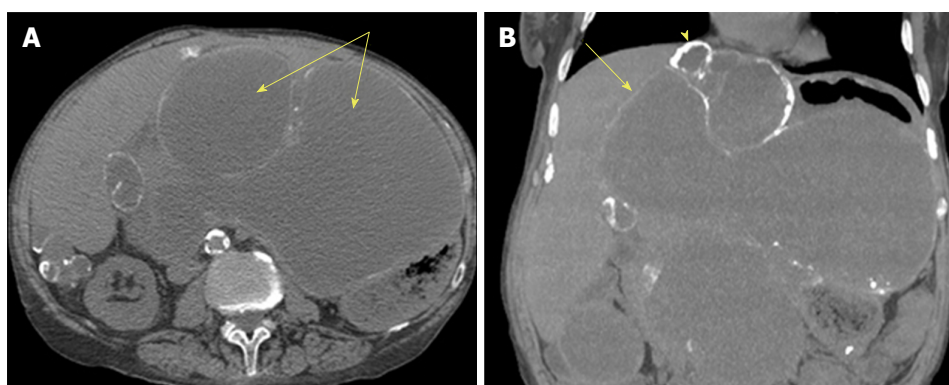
Computed tomography of pseudomyxoma peritonei^[26]. This is an axial computed tomography scan. A: Cystic accumulations of mucus (arrows) surrounded by calcified rims; B: A coronal reconstruction representing cystic accumulations in the upper abdomen and the liver.
